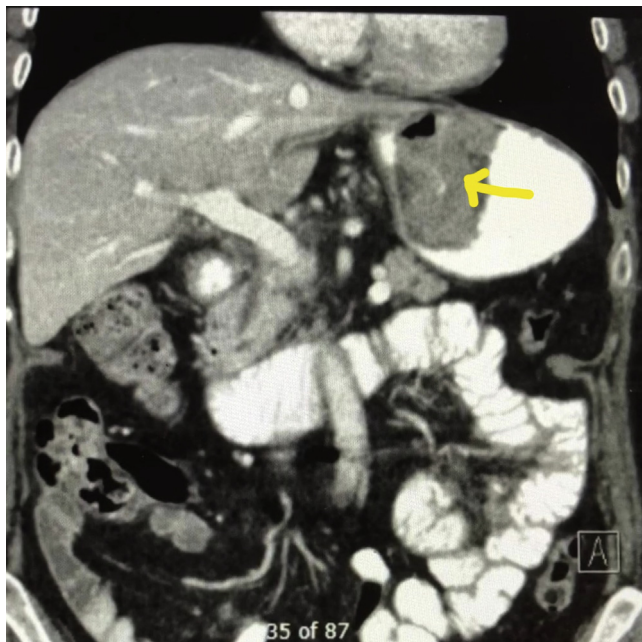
CT view of the abdomen demonstrating a large gastric cardia mass.
